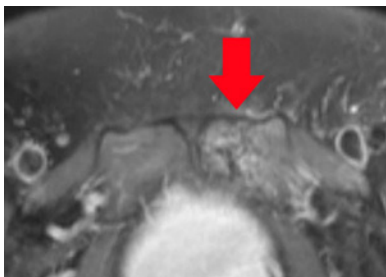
T2 weighted MRI in a transaxial orientation showing a lesion in the left pubic body (red arrow) suggesting fracture.
